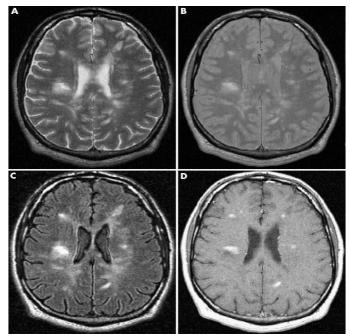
Transverse MRI section of a 30-year-old male with RRMS showing periventricular lesions.
